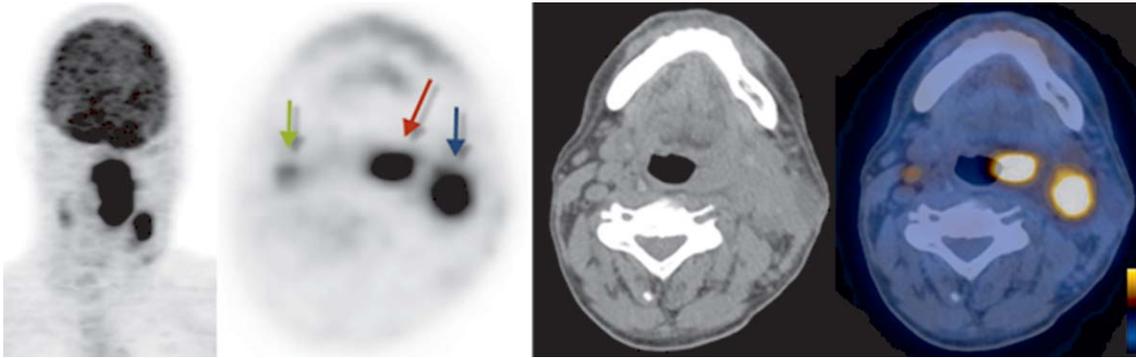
Squamous cell cancer of the left mesopharynx, midline crossing, only ipsilateral lymph node metastasis. From left to right: "Maximum intensity projection" PET image (MIP), axial PET, CT, and fused PET/ CT. SUV primary tumor 16 (red arrow), ipsilateral lymph node 7.2 (blue arrow), contralateral lymph node 4.0 (green arrow).
